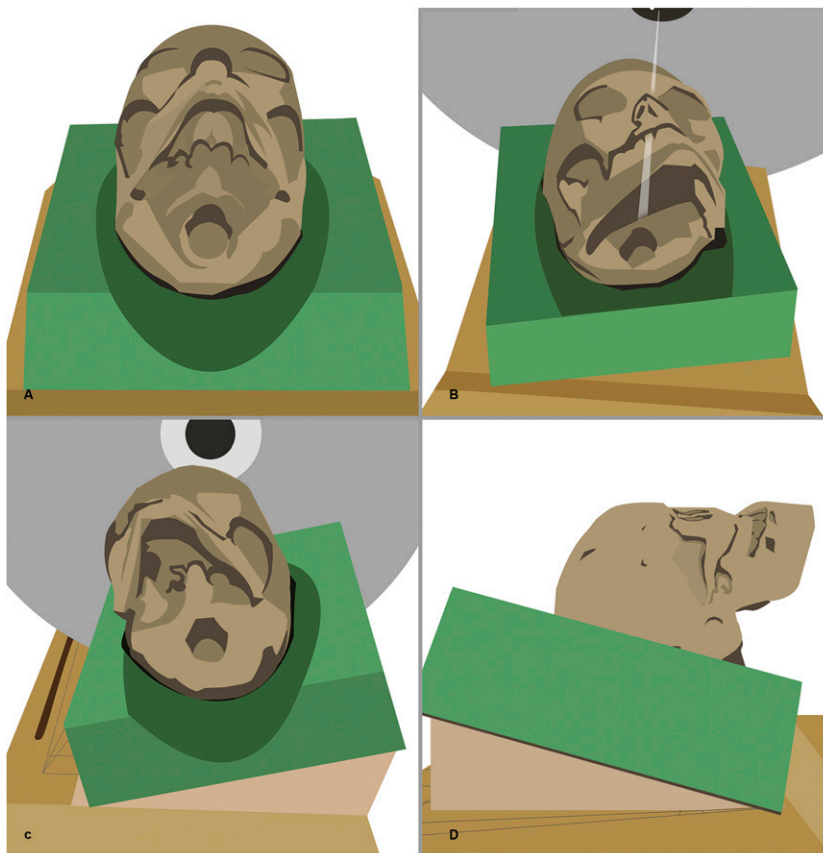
Taking CBCT scans of the skulls in central position (a), tilted position (b), rotated position (c) and tipped position (d).
